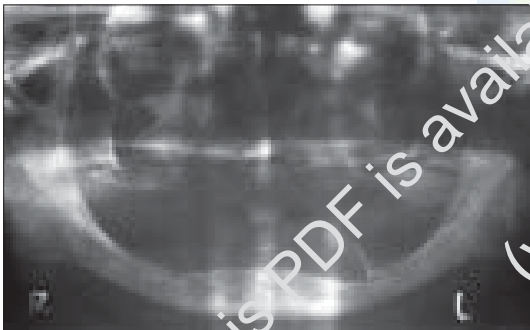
Orthopantomograph showing severely resorbed maxillary and mandibular alveolar bone
